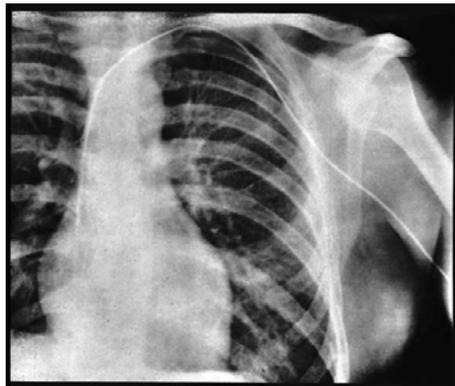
Werner Forssmann's X-ray showing cardiac catheterization
